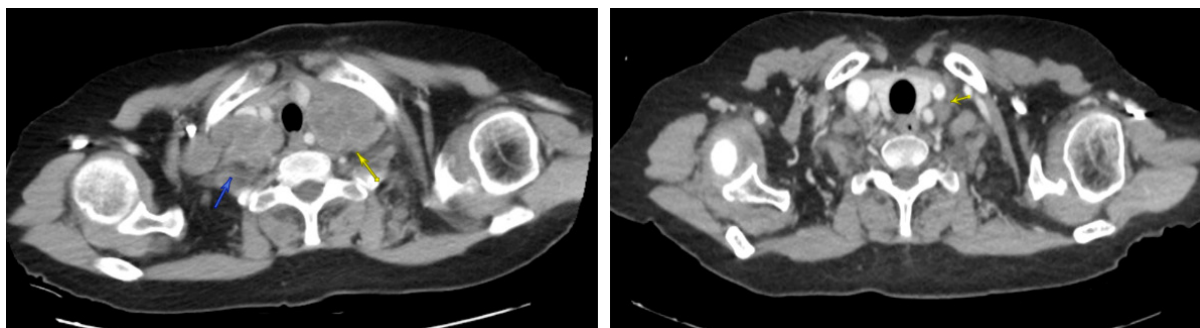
CT scan of the neck before and after Temozolomide treatment
